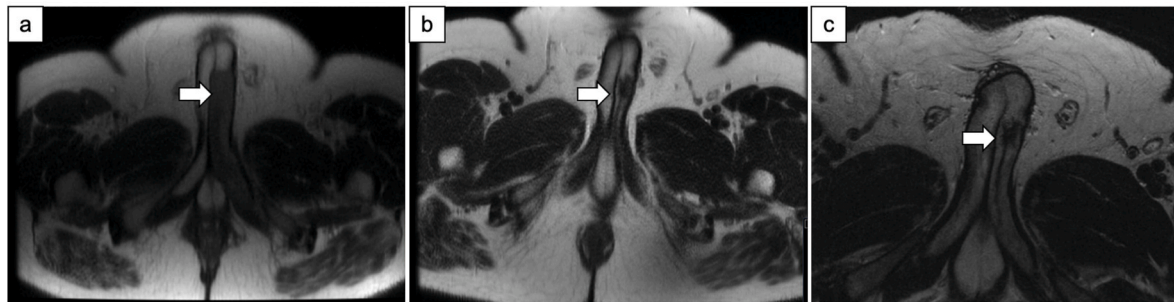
(a) Initial MRI at presentation with 11.5cm segment from the base to the midportion of left corpora cavernosum with restricted diffusion. (b) Repeat MRI at 4-month interval with 2.1cm area of T2 hypointensity in the left corpus cavernosum at the midportion of the penis decreased from prior. (c) Repeat MRI at 8-month interval with stable 2.1cm area of T2 hypointensity with loss of peripheral enhancement consistent with scar formation.
